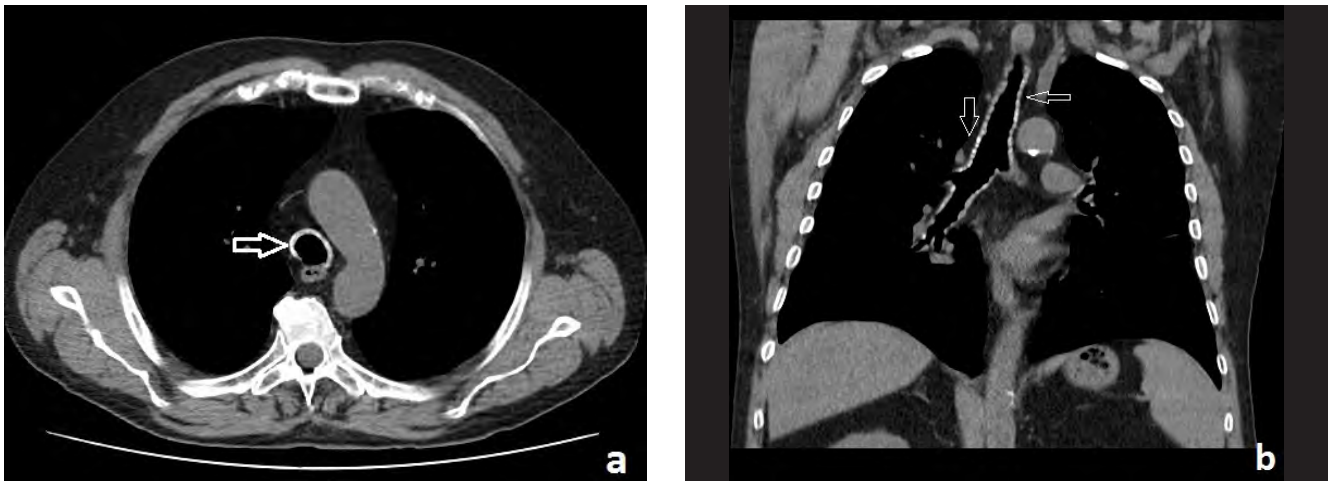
Axial (a) and coronal (b) views of high resolution CT thorax showing calcification and submucosal nodular pattern (arrows) along the trachea and major bronchi.
